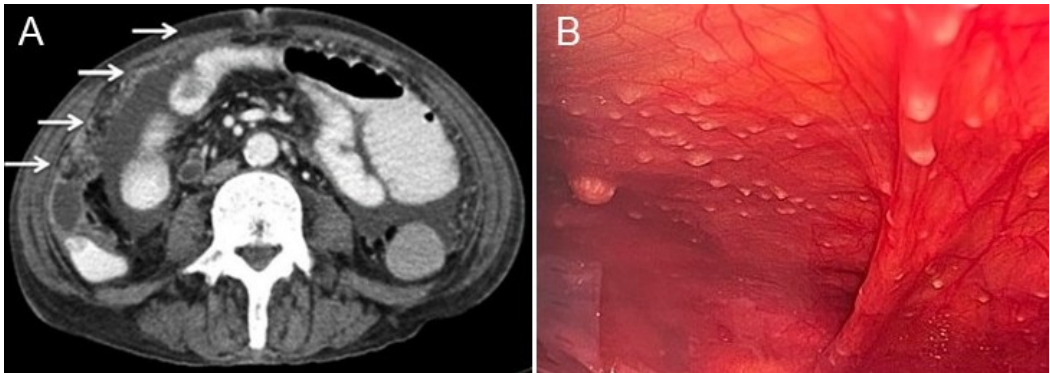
Peritoneal tuberculosis. A. Abdominal computed tomography (axial view) showing nodular peritoneal thickening (arrows) associated with interloop loculated fluid collections in both paracolic gutters, findings suggestive of an intra-abdominal inflammatory process; infiltrative etiology cannot be excluded. B. Laparoscopic image showing multiple miliary nodules on the parietal peritoneum, consistent with tuberculous involvement.
